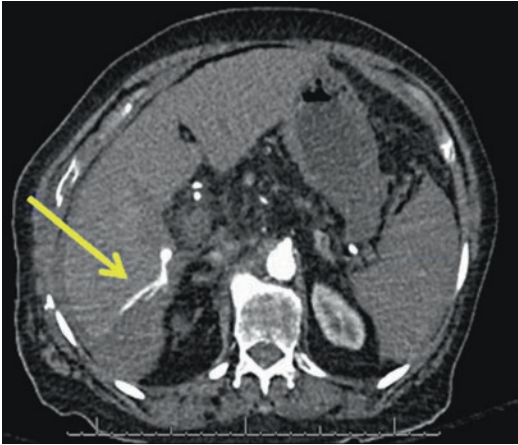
CT Scan abdomen, Grade 2 liver laceration with active contrast extravasation
